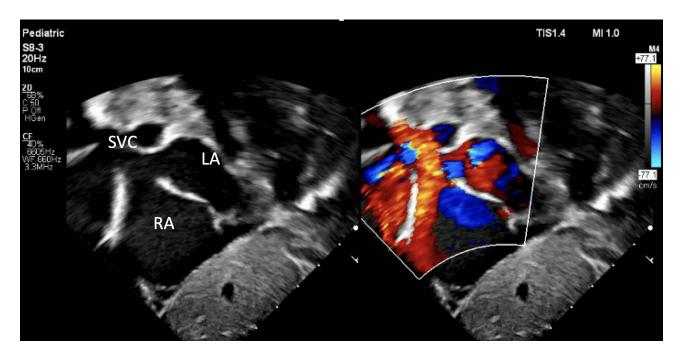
Echocardiography Revealing Sinus Venosus Atrial Septal Defect (ASD) with Partial Anomalous Pulmonary Venous Return (PAPVR) of Right Upper Pulmonary Vein (RUPV) to Right Atrium (RA).
